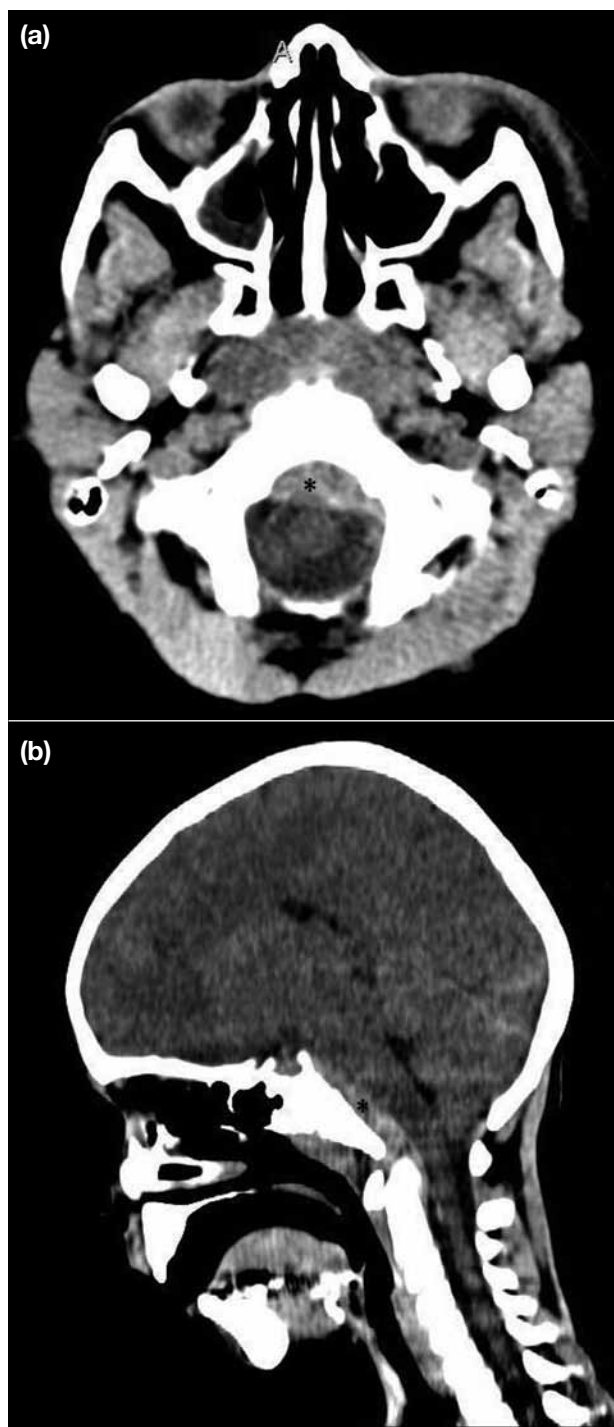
Initial (a) axial and (b) sagittal computed tomographic scans showing the retroclival epidural haematoma (*) anterior to the brain stem and posterior to the clivus and obliterating the prepontine cistern, measuring 9 mm in thickness.
